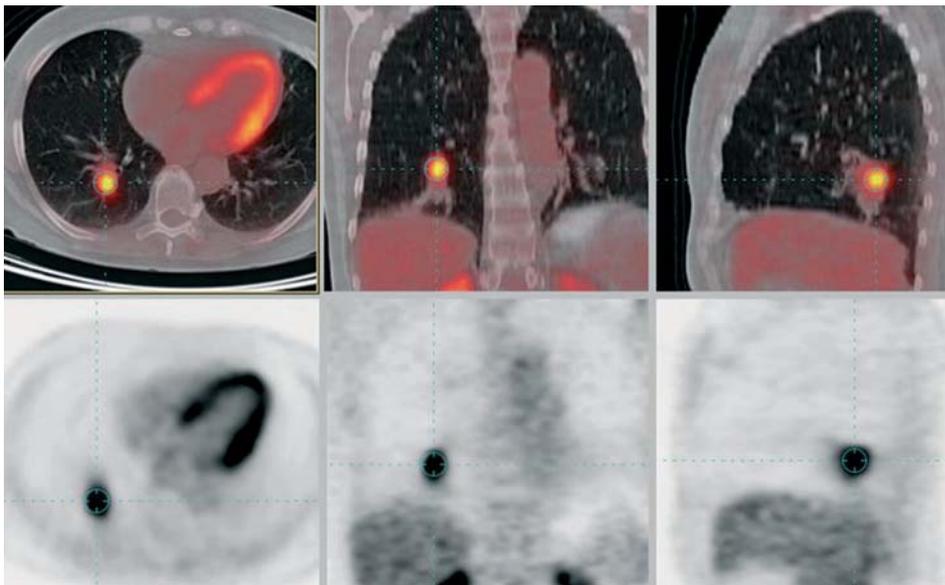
Characterization of a right lung nodule of unknown etiology. Positron emission tomography–computed tomography: nodular lesion suggestive of a tumor in segment 10, right.
